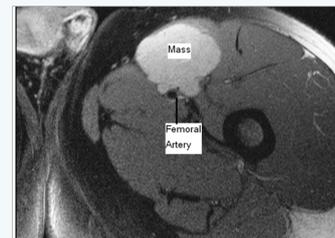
MRI coronal view showing mass encasing vessel.
